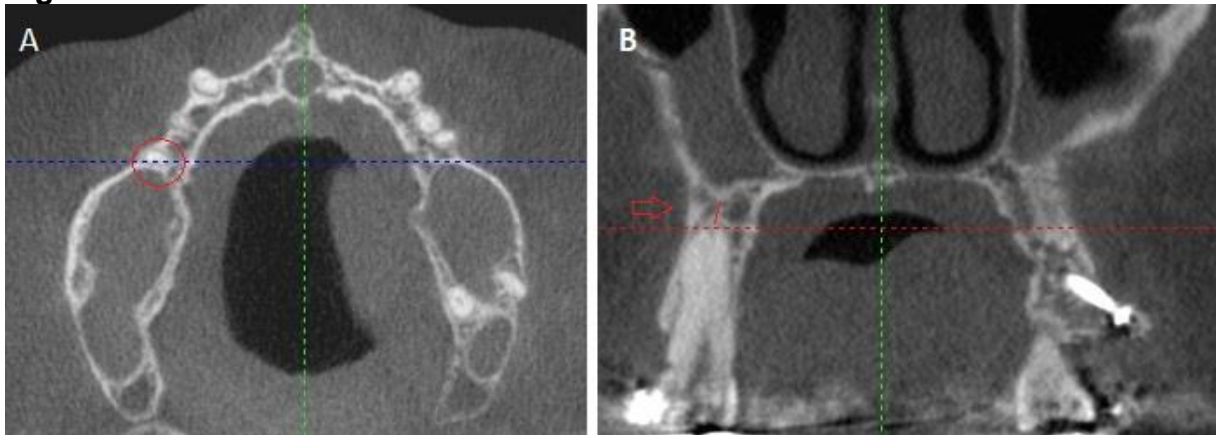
CBCT image demonstrating (A): axial section selected for a root apex and (B) correspondent coronal section for acquisition of distance between root apex and MS.
